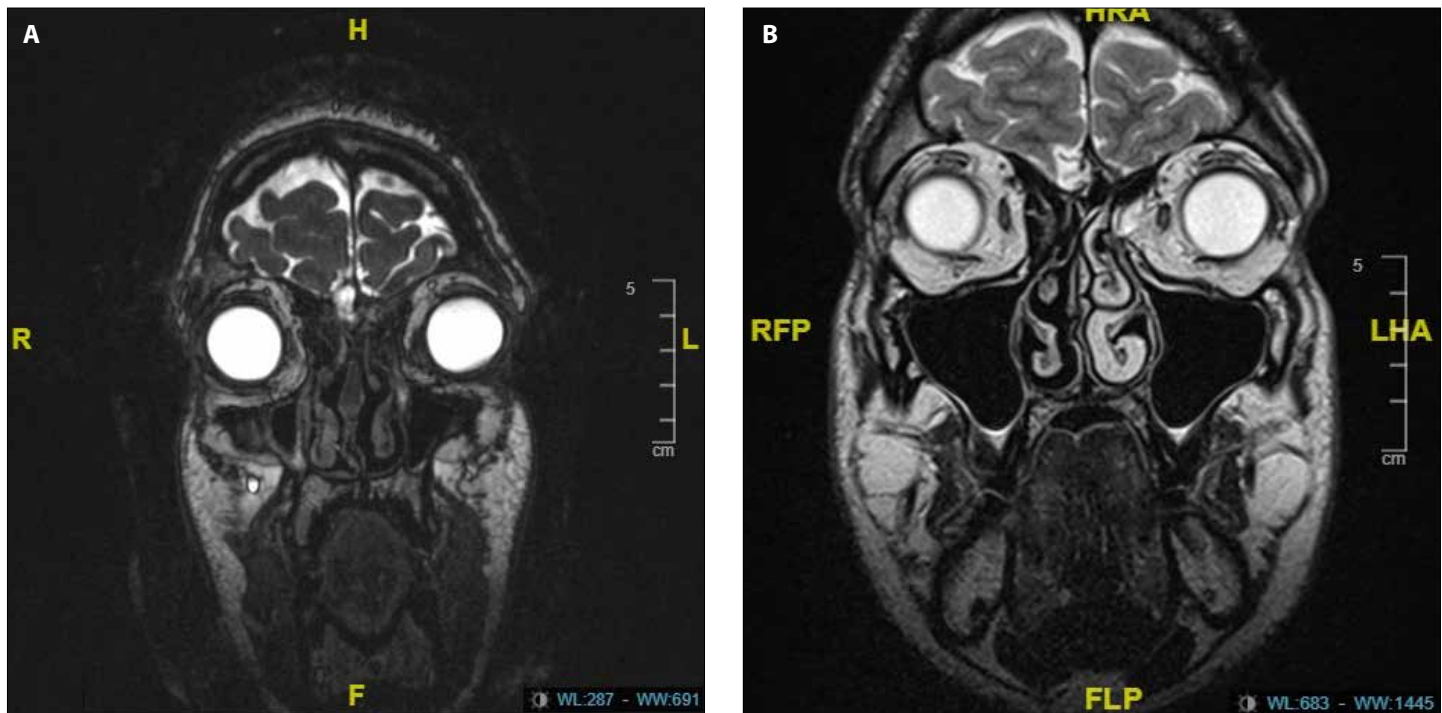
A, B. Preoperative scan with coronal (A) sequence demonstrates a dural defect at the right cribriform plate just lateral to the crista galli. The coronal (B) from the postoperative MR imaging reveals postoperative changes at the right olfactory groove
